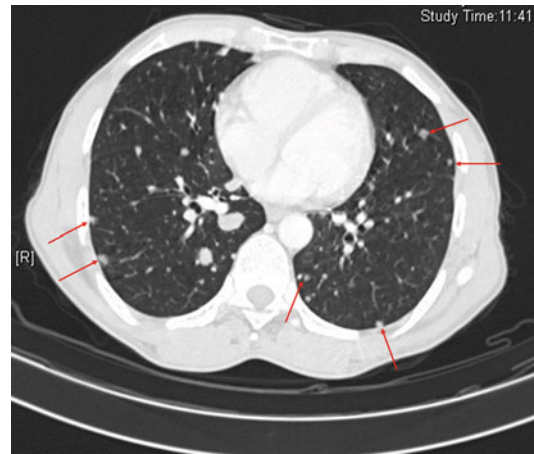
Contrast-enhanced CT thorax axial sections showing multiple metastatic lung nodules (some shown by red arrows)
